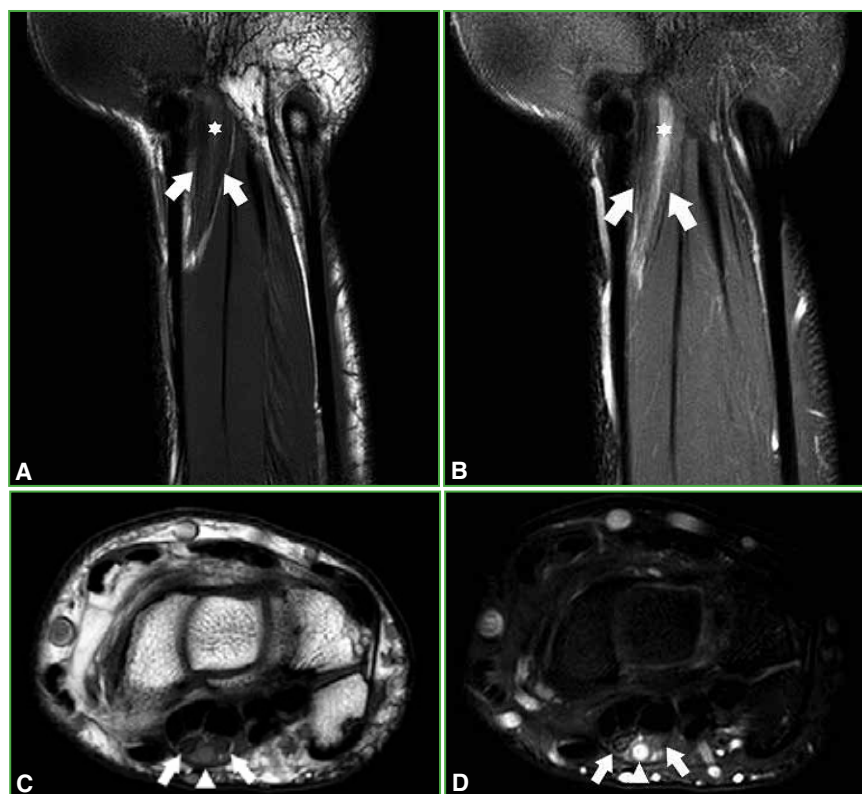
Non-contrast magnetic resonance imaging of the right wrist. A and B. Coronal T1 and STIR sequences, respectively. Median nerve with bifid morphology (arrows) with a hyperintense tubular image (asterisk). C and D. Axial T1 and STIR sequences, respectively. Divided median nerve (arrows) with rounded mass in the middle (arrowhead).
